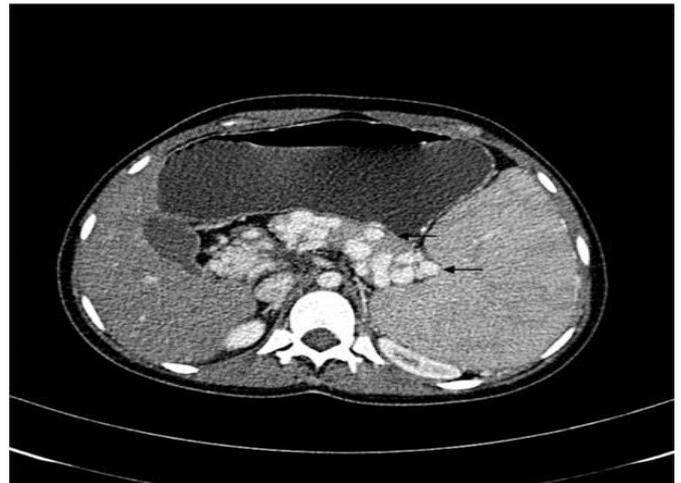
Axial CT portal venogram scan in a patient with extrahepatic portal hypertension shows replacement of the entire portosplenic venous axis by multiple peripancreatic collaterals (←) and portal cavernoma formation.
